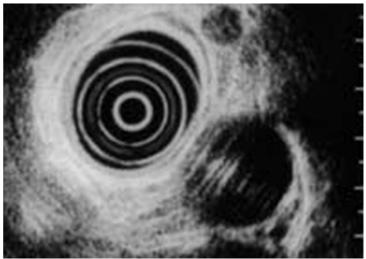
Endosonography with lymphadenopathy (clinical metastasizing bronchial cancer), normal thoracic aorta
